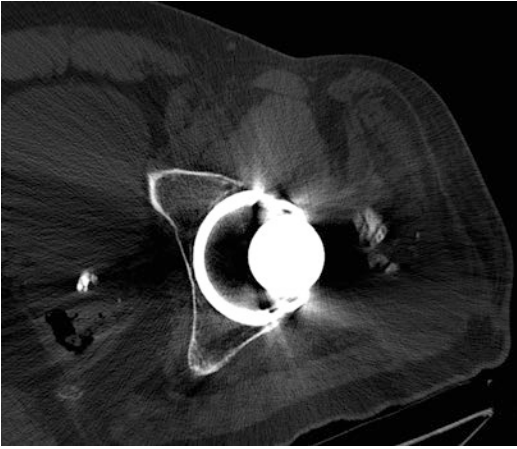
CT scan of the pelvis of the patient prior to final revision. The acetabular component does not demonstrate adequate anteversion
